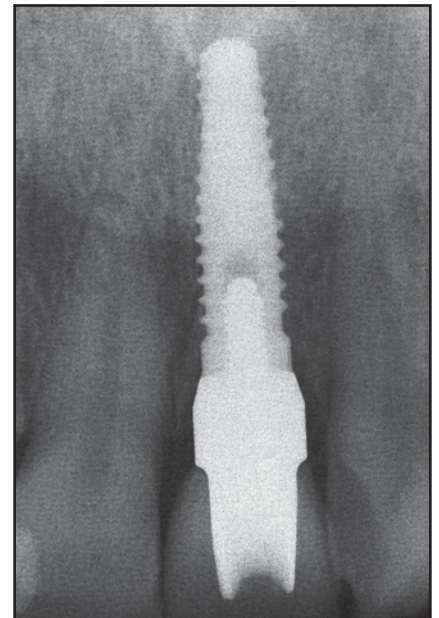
(right) Postoperative radiograph at 1 year.
